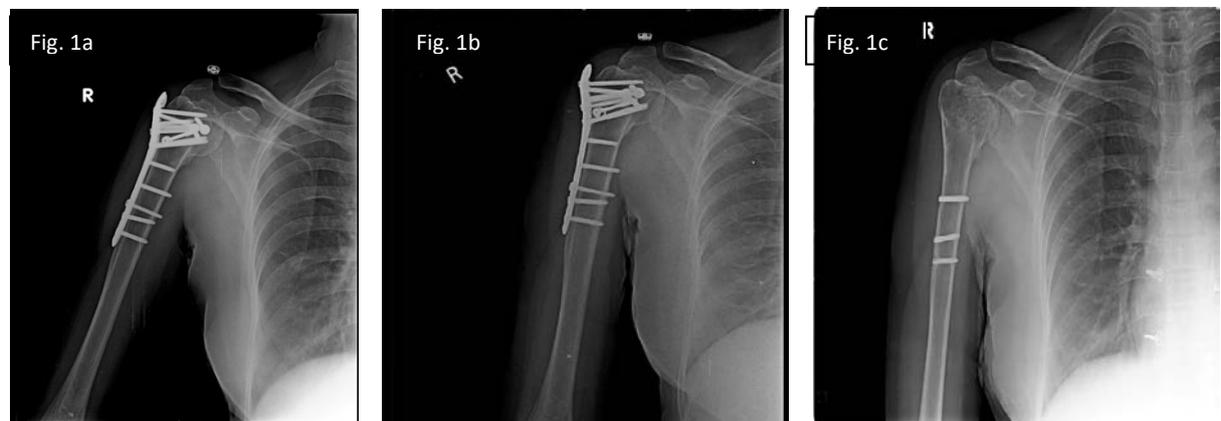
The plane radiographs (AP views) of a case of self-fall, treated with Proximal Humerus internal locking system (PHILOS) a) immediate postoperative view b) 6 months follow up c) 12 months follow up (PHILOS removed)
